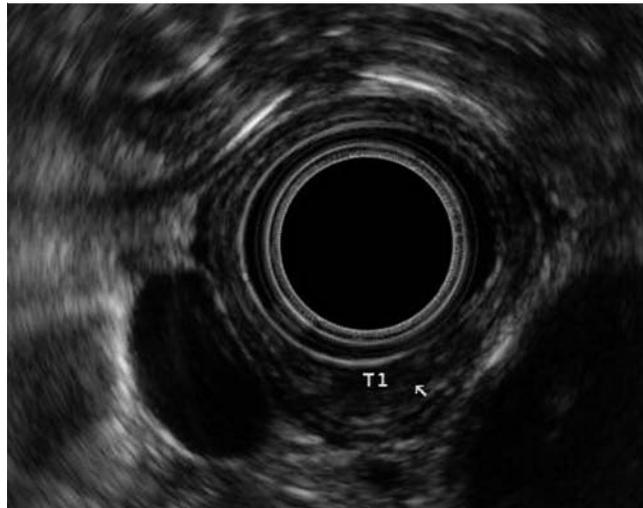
Endoscopic ultrasound view of the esophageal tumor (T1).
